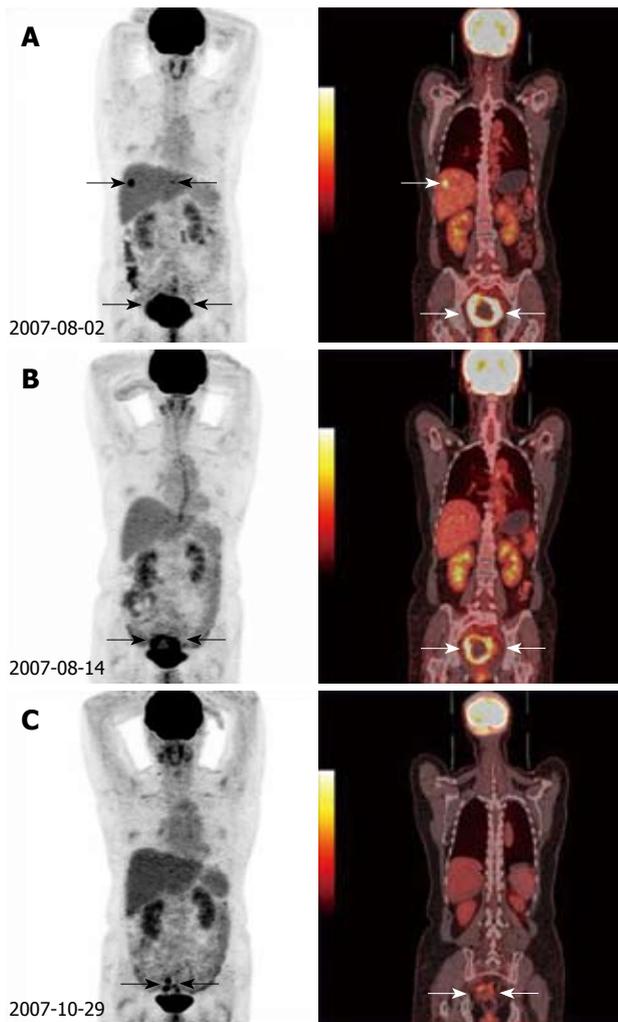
Monitoring responses to pelvic recurrence and liver metastases. Three PET/CT scans were obtained in a 55-year-old woman five months after rectal cancer resection. A: PET/CT demonstrated a locoregional recurrence and liver metastasis foci (arrows) before salvage treatment; B: PET/CT showed obvious decreasing of intense activity after two cycles of chemotherapy (arrows); C: After six cycles of chemotherapy, PET/CT imaging follow-up revealed good control of pelvic recurrence and liver metastases (arrows).
